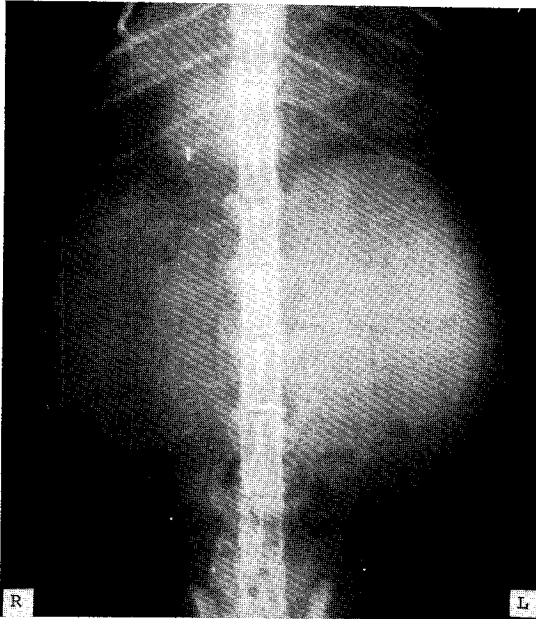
Abdominal radiograph: enlargement of both kidneys is present, much greater on the left than right.
